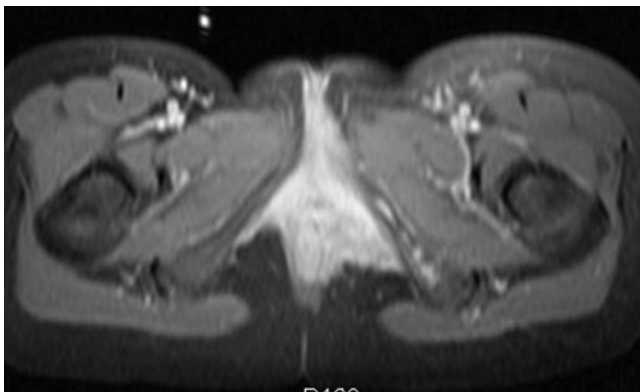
Vaginal rhabdomyosarcoma in a 14-year-old female. Transverse gadolinium-enhanced T1-weighted fat-suppressed spin-echo image demonstrates an irregular enhancing mass extending outside the vagina to involve the vulva and perineal region. Enhancing bony metastasis of the left inferior pubic ramus is also seen.
